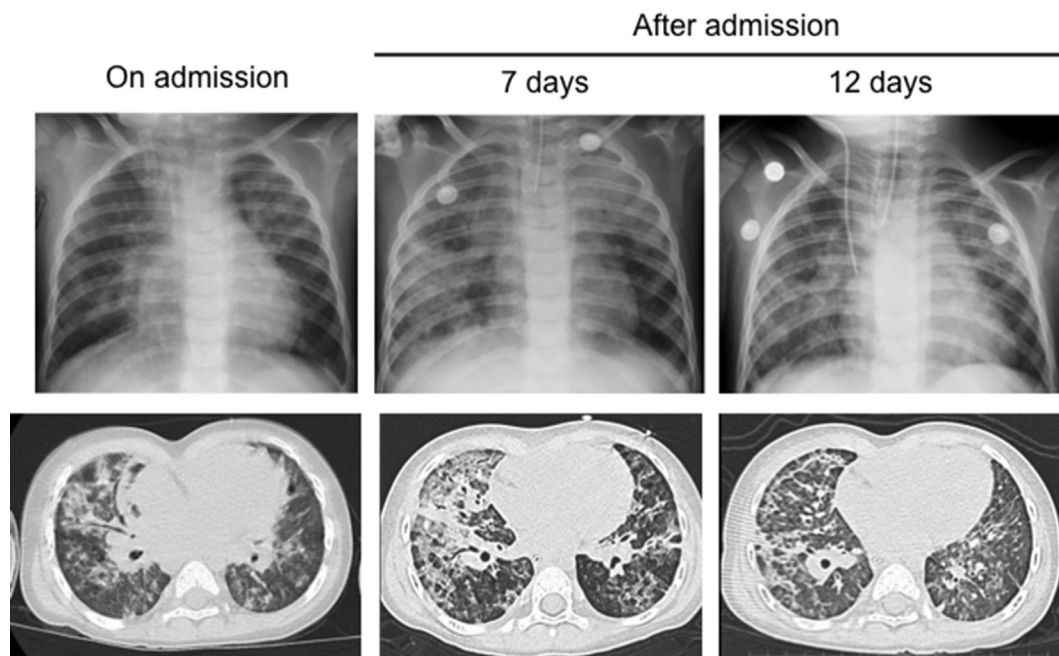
Chest imaging. Patchy shadows in both lungs along the bronchial tube, accompanied by air bronchogram were prominent on admission. An enhanced reticular shadow was observed in the radiograph, and patchy, funicular and frosted glassy shadows were visible along the bronchial tube by computed tomography on 7 days after admission. On 12 days after admission, the frosted glassy shadow improved. Upper panel: simple chest radiograph, lower panel: computed tomography
